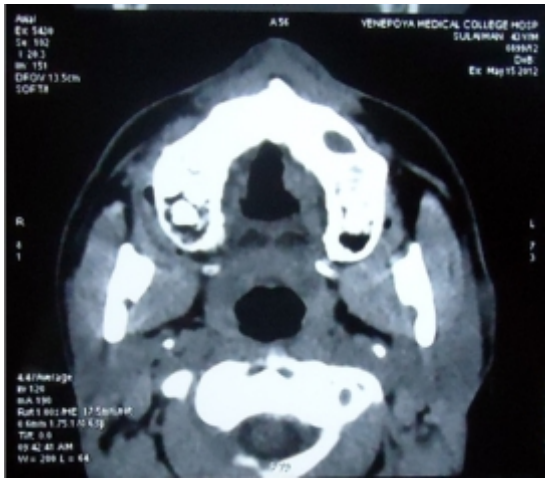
CT soft tissue profile (axial view) showing mucosal thickening
